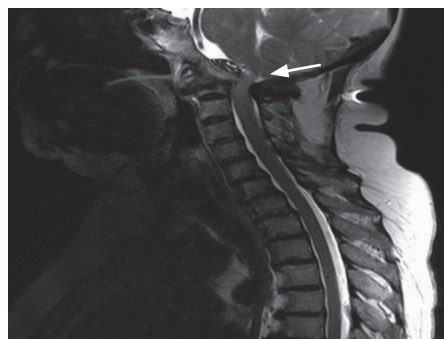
A T2-weighted magnetic resonance imaging of the sagittal cervical spine shows compression of the medulla oblongata by periodontoid pannus (shown by the arrow).
